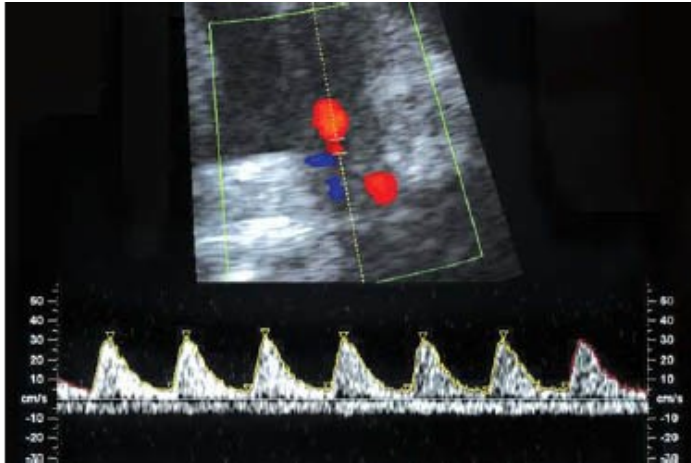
Ultrasound image with color Doppler showing the umbilical cord, red umbilical artery and blue umbilical vein (left). Normal flow velocity waveforms from the umbilical vein (bottom) and artery (top) at 32 weeks of gestation.
